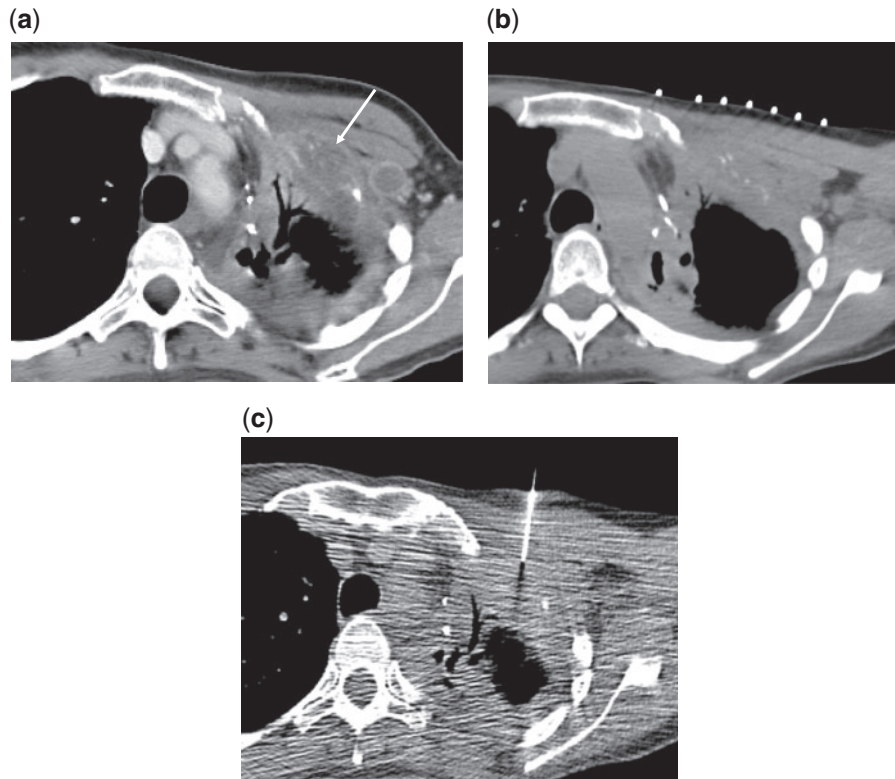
A 55-year-old woman with a history of lung cancer and previous radiation therapy who presented with axillary lymphadenopathy and an infiltrative soft tissue mass involving the left anterior chest wall. (a,b) Contrast-enhanced CT scan reveals an enhancing infiltrative soft tissue mass involving the left anterior chest wall (arrow). (c) Unenhanced CT scan obtained during biopsy with a 22-gauge needle (arrow); cytopathology revealed metastatic lung adenocarcinoma.
